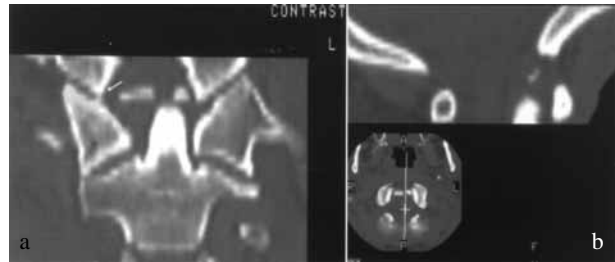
a. CT 2D coronal reconstruction shows : Left : Avulsion of the apex of odontoid process which is displaced to the left. Fracture of the medial side of the right occipital condyle which appears to be blunt (arrow) as compared to the left side. The avulsed fragment corresponds to the insertion of the right alar ligament. The right lateral mass of C1 appears to be thinner than the left because of its anterior displacement. Right upper corner : CT mid-sagittal reconstruction demonstrates avulsion of apical ligament. b. CT : Right lower corner : transverse CT shows two bone avulsions.
